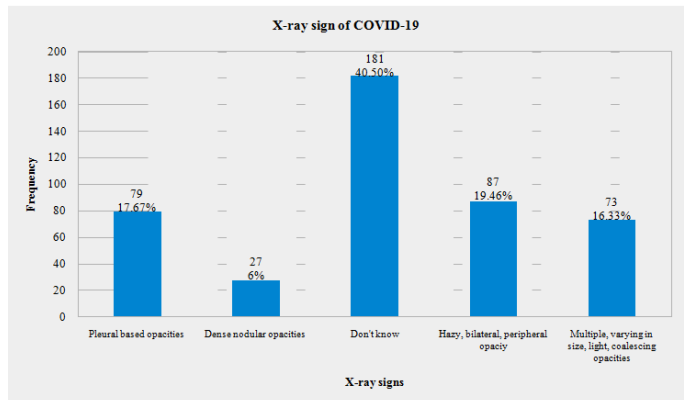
Awareness among respondents regarding signs of COVID-19 on X-ray (n=447)
